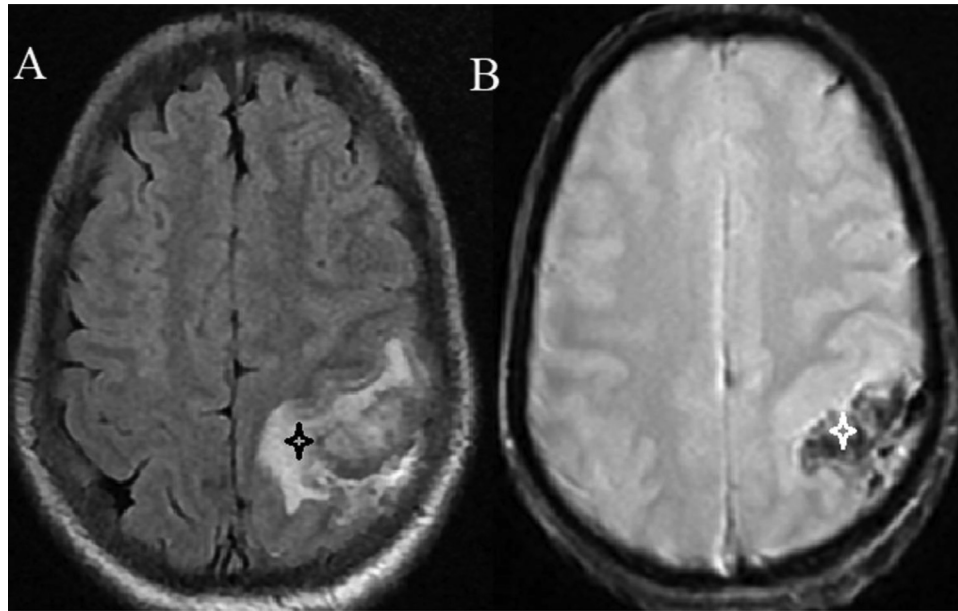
Cranial MRI on axial Flair sequence (A) shows hypersignal intensity of the left precentral gyrus surrounding hypointense signal in the left parietal lobe (black asterisk). T2*-weighted gradient-echo sequence (B) demonstrates hypointensity lesion in the left parietal lobe (white asterisk).
